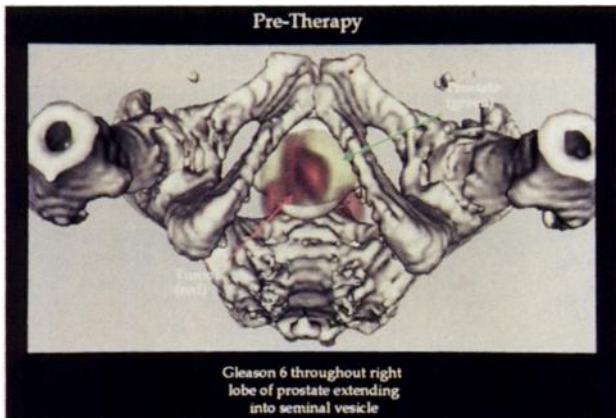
Fused image of ¹¹¹In prostate monoclonal antibody with an MR image of the pelvis. It can be seen that the cancer, shown in red, extends beyond the capsule of the prostate to involve the seminal vesicles. This tells the urologist that the lesion should be treated with external radiation therapy directed toward the lesions defined in the ¹¹¹In image, rather than by prostatectomy or radioactive seed implants (#232).
